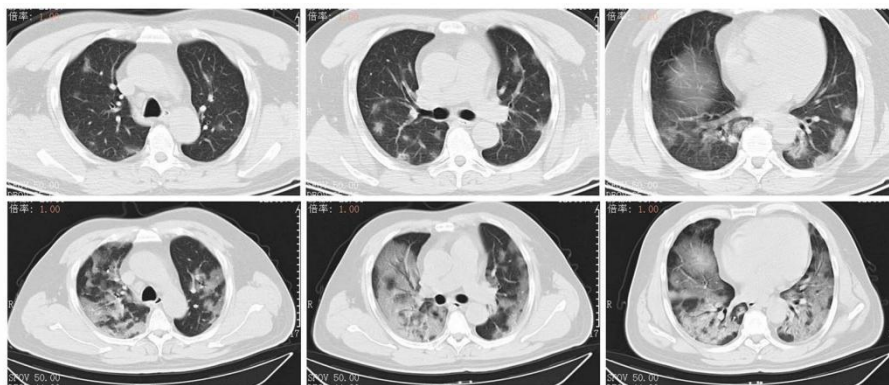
Top Row: chest CT obtained on Jan 10 (3A) showed mass shadows of the patchy glass in both lungs, which were distributed along the bronchial bundle and subpleurum.
